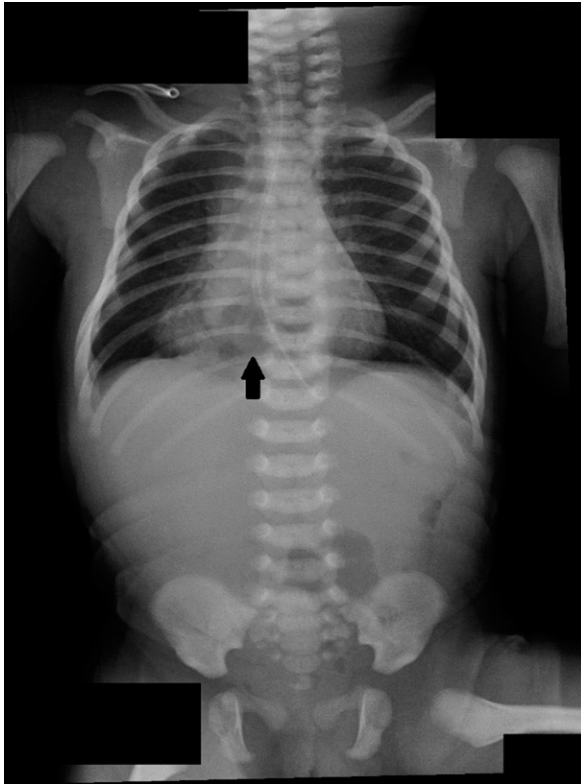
Radiograph depicting a 'gasless' abdomen. The black arrow points to a cystic lucency projecting over the lower mediastinum.
